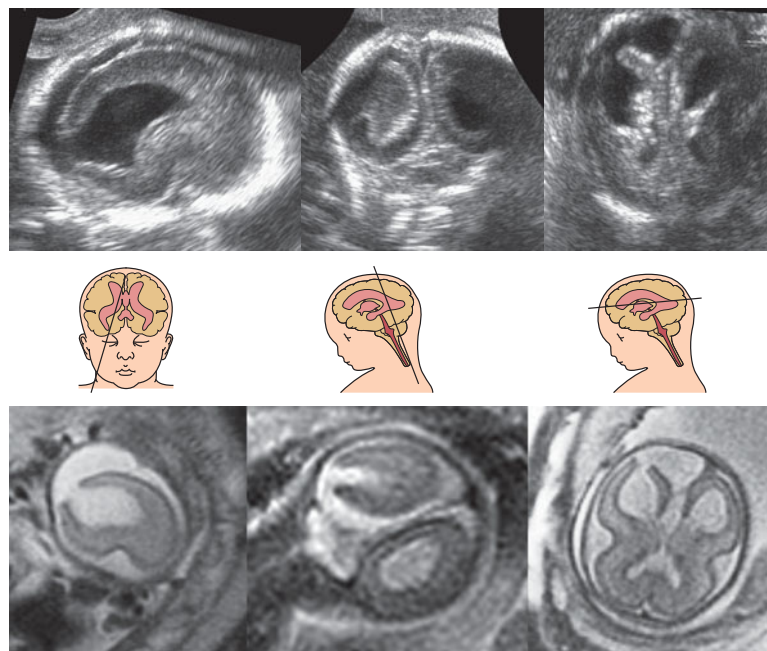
Comparative US (*upper row*) and MRI (*lower row*) of a unilateral, right-sided, open-lip schizencephaly. Sagittal, coronal, and axial planes, respectively (same case as in Figures 10-7 and 10-8).
